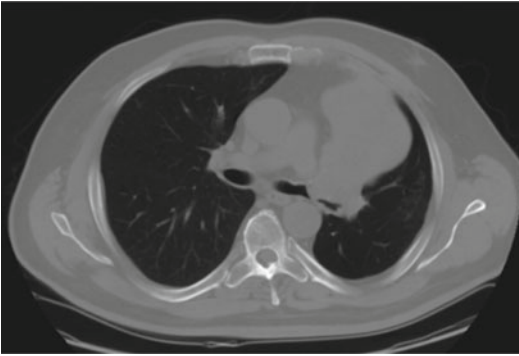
CT image of a large central carcinoid tumor emanating from the left upper lobe bronchus into the left mainstem bronchus. This tumor required a bronchial sleeve resection to achieve negative surgical margins. Note the complete collapse of the left upper lobe resulting from the airway obstruction
